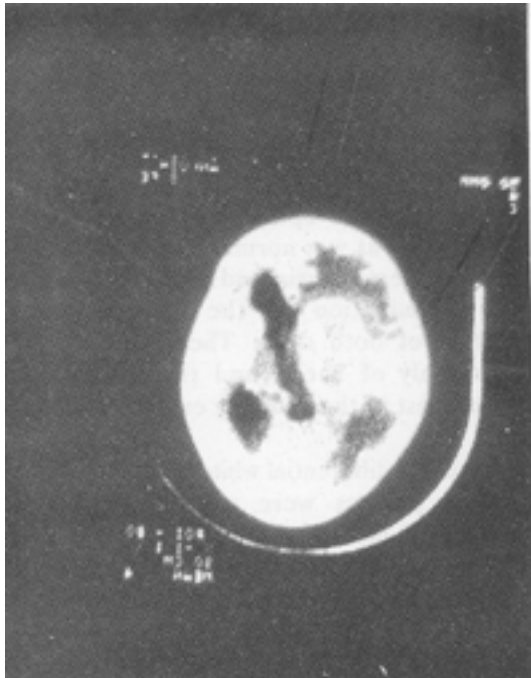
CT scan showing a large ring enhancing lesion in right temporoparietal region and dilated left ventricle
